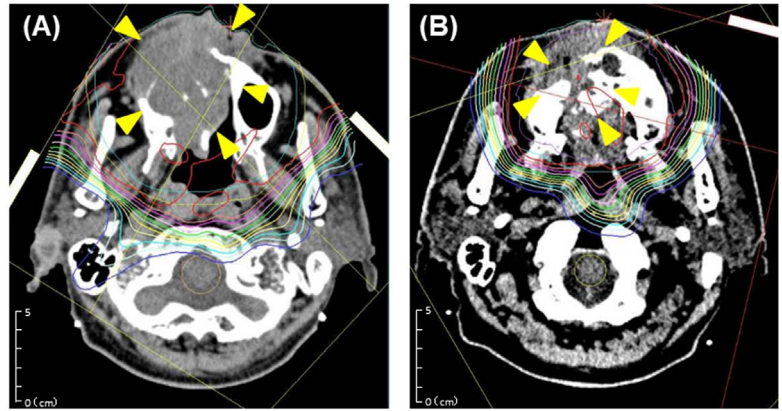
Dose distribution of proton beam therapy by axial computed tomography. (A) First plan: 45 Gy (RBE) in 18 fractions. (B) Boost plan: 26.4 Gy (RBE) in 12 fractions. Total dose was 71.4 Gy (RBE). Left eye, left optic nerve and optic chiasma were discharged totally in the boost plan. Yellow arrows indicate tumors. RBE, relative biological effectiveness.
